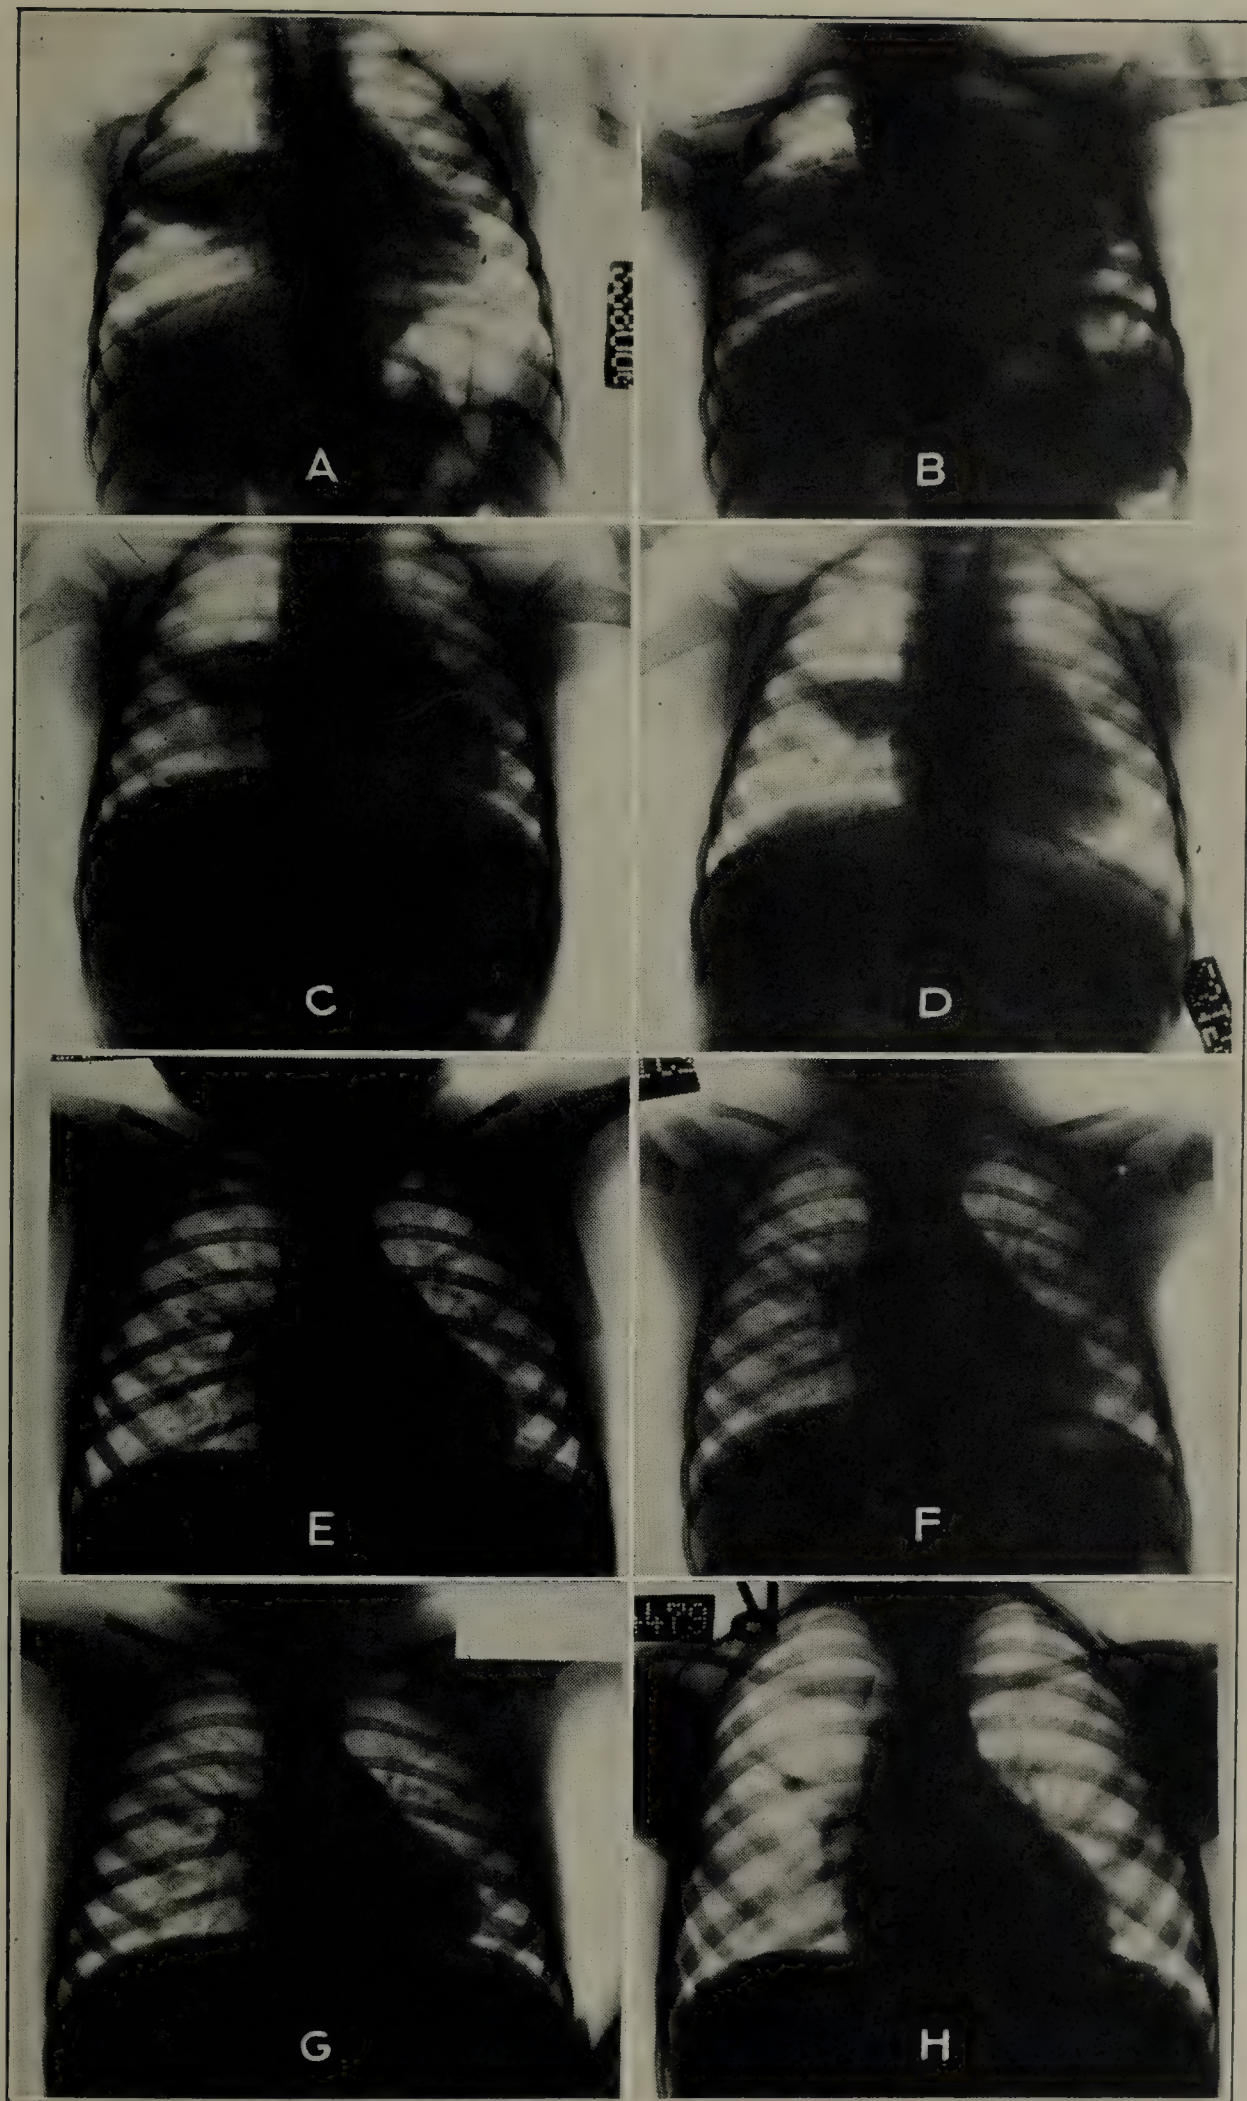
ROENTGENOGRAMS SHOWING EVOLUTION AND RESOLUTION OF A PRIMARY PULMONARY FOCUS.
